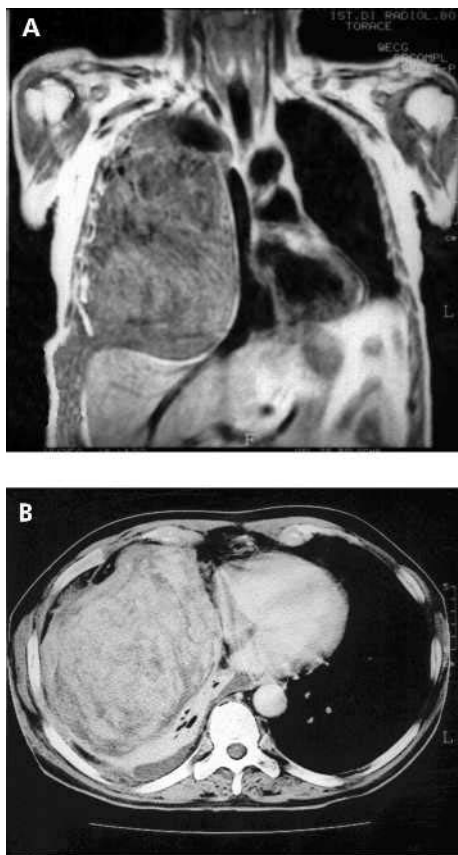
(A) Preoperative CT scan and (B) preoperative MR scan of the thorax.
